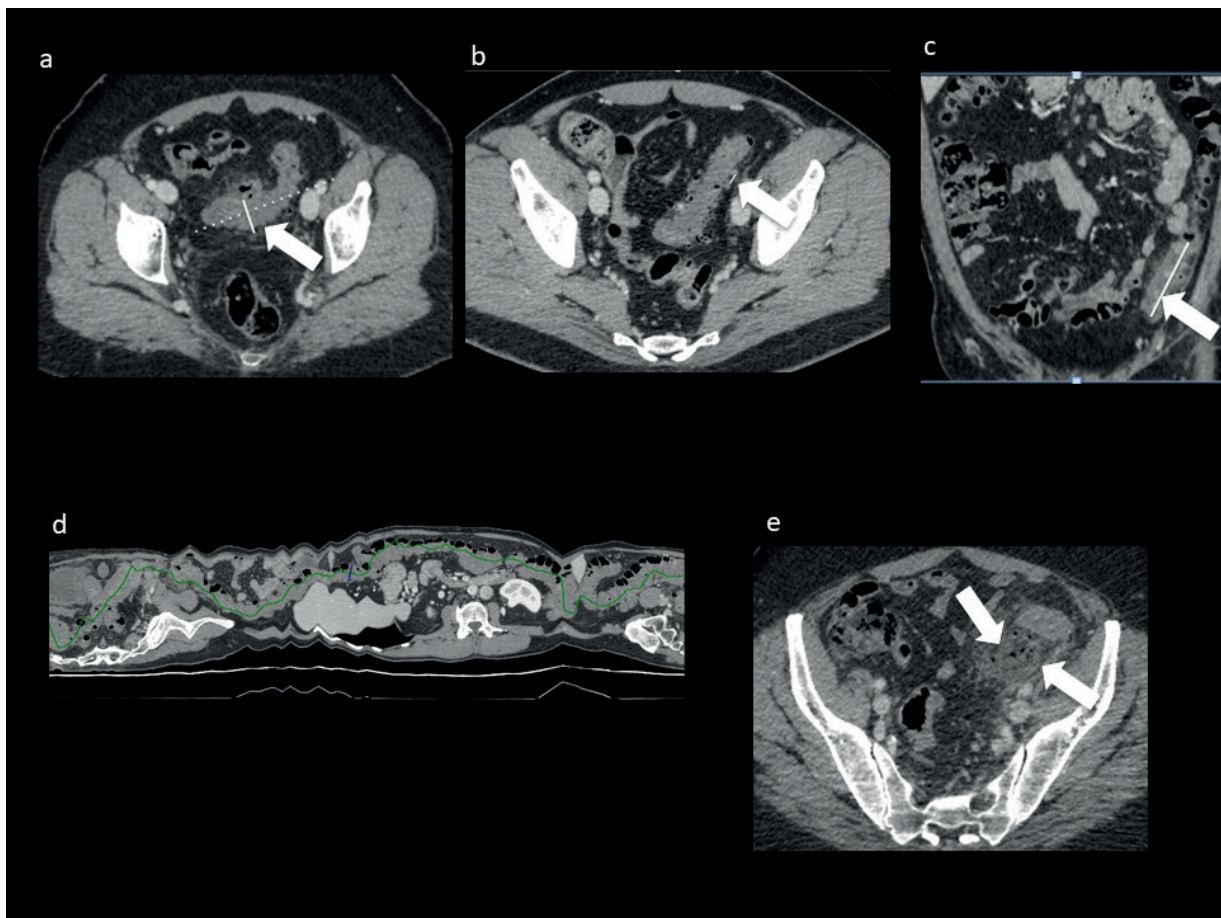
The five CT-scan parameters considered for each patient: a) Colonic segment involved, b) Thickness of inflamed colonic wall, c) Length of involved colon, d) Diverticula density and e) Presence of microperforation.
